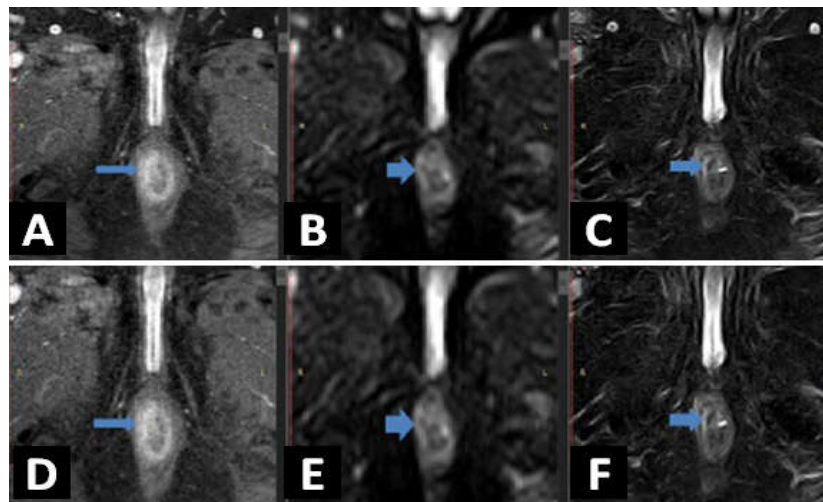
57 years old male, presented with Rt. sided perianal discharge, grade II inter-sphincteric fistula, A= axial T1 PC. B= DWI. C= T2 Fs (internal opening). D= axial T1 PC. E=DWI. F=T2 Fs (main tract).
